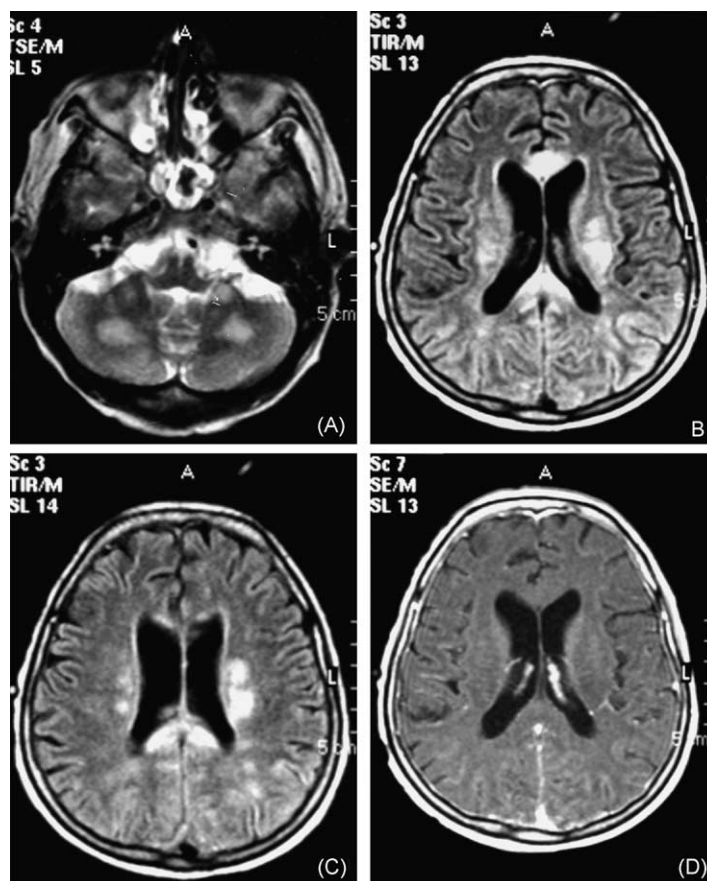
(A) T2 weighted image (T2 WI) (TR/TE, 4000/100) shows hyperintense lesions in both cerebellar hemispheres. (B) Oedematous lesions in the corpus callosum and (C) white matter are seen on FLAIR (TR/TE/TI, 5000/100/1900) images. (D) Lesions do not enhance with contrast material (Gd-DTPA) on T1W SE (TR/TE, 550/15) imaging. Note that diffuse superficial hyperintensity with an effacement of the sulci, more prominent posteriorly on FLAIR (A, B) and leptomeningeal enhancement on postcontrast T1W SE images (D).
